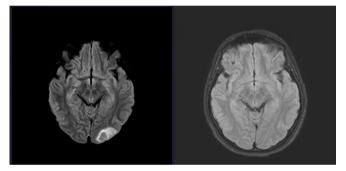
Antenatal MRI and postnatal 40th day control MRI image of a 35w pregnant patient (Left MRI: area of hyperintense vasogenic edema in cortical and subcortical T2W-FLAIR image in the left occipital lobe; Right MRI: T2W-FLAIR hyperintense edema area disappeared in the control MRI of the same patient.)
